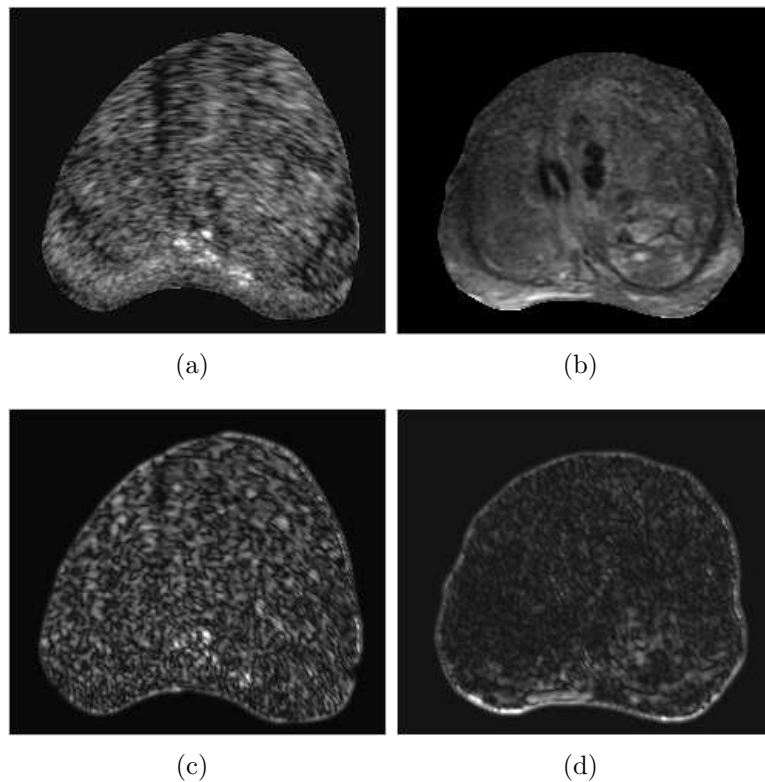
Application of quadrature filters on TRUS and MR images. (a) and (c) are the fixed TRUS image and its corresponding quadrature texture; and (b) and (d) are the moving MR image and its corresponding quadrature texture respectively.
